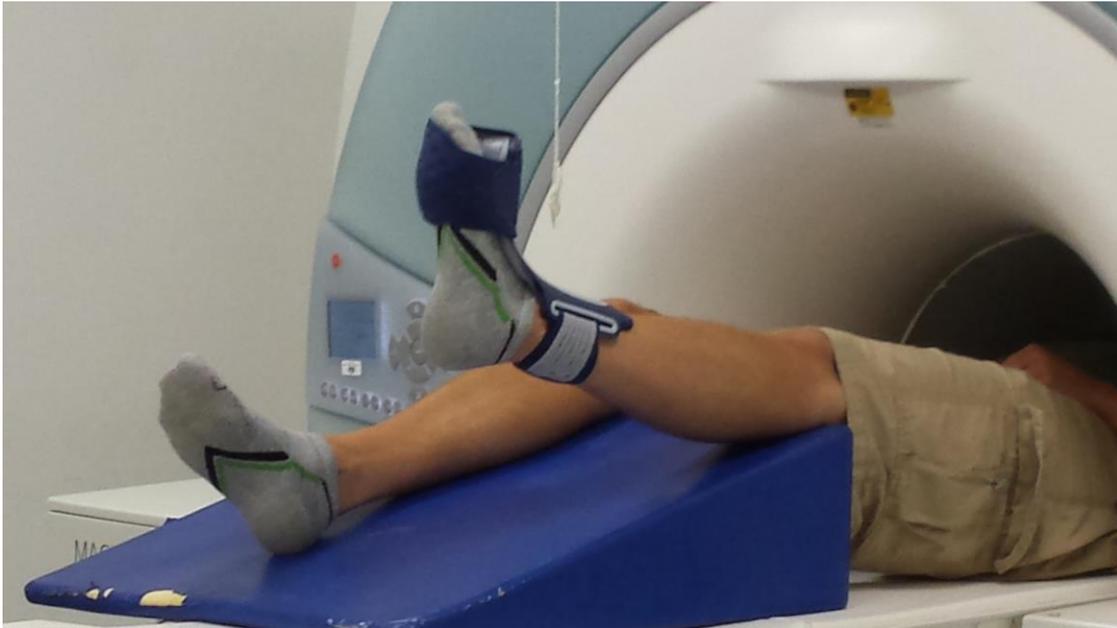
Leg Movement Task Using MRI. Participant moving their leg in the external focus condition while inside an MRI scanner. The hanging target was removed during the control and internal focus conditions.
